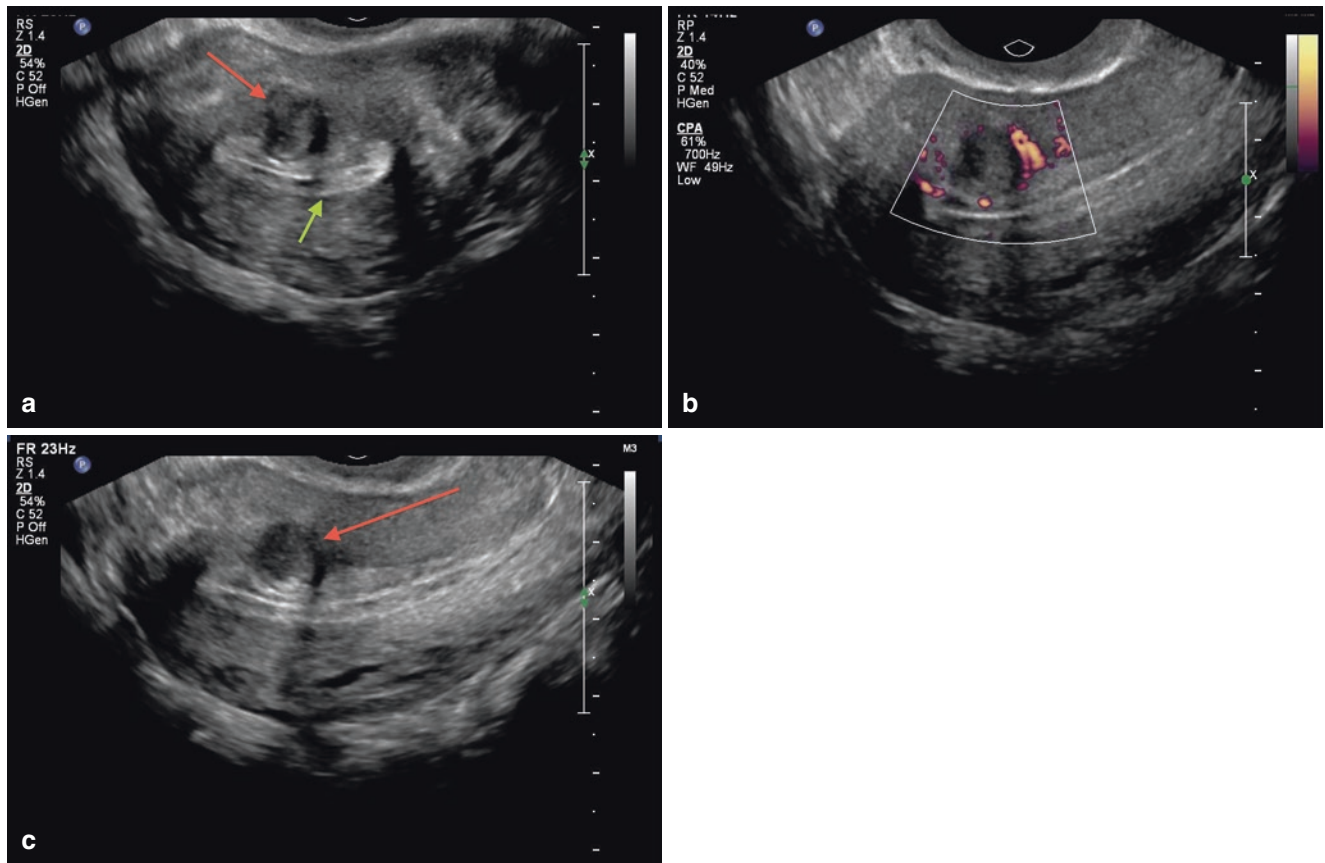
(a) Axial ultrasound section of the uterine fibroid, showing myoma (*red arrow*) with submucosal component, less than 50%, and mostly with intramural component. The *green arrow* indicates the endometrial echo. (b) Longitudinal ultrasound section of the uterus, showing peripheral vascularization in the myoma, in a study with power Doppler. (c) Same myoma (*red arrow*) in longitudinal section, showing greater intramural than submucosal component. Note the narrowing of the anterior portion of the endometrium
